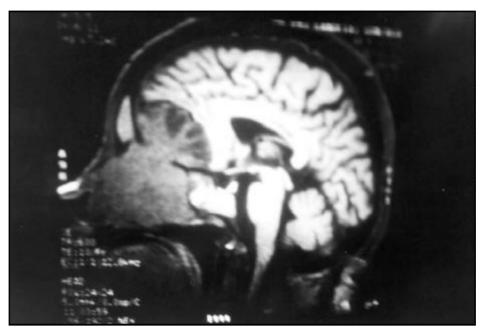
Preoperative sagittal MRI of the tumor, involving the ethmoid sinus, sphenoid sinus, nasal cavity and frontal lobe.
